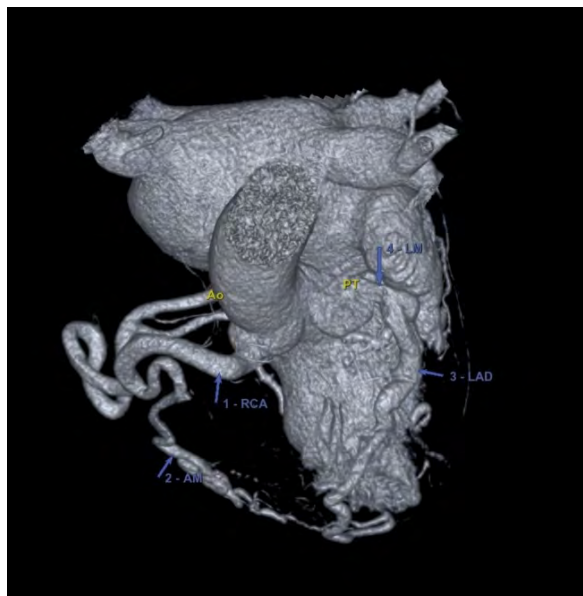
Coronary computed tomography angiography — 3D reconstruction of coronary arteries. Ao — aorta, PT — pulmonary trunk, RCA — right coronary artery, AM — marginal artery, LAD — left anterior descending artery, LM — left main coronary artery
